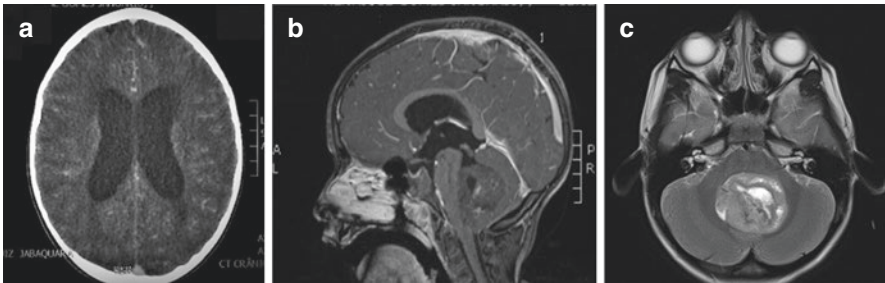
An eleven-year-old boy presenting with headache and vomiting. Imaging exams showing a posterior fossa tumor in the IV ventricle. Pathology demonstrating medulloblastoma. (a) Axial CT scan showing enlargement of the lateral ventricles, Evan's ratio greater than 30%. (b) Sagittal MRI T1-WI contrast enhancement demonstrating a posterior fossa mass, thinning of the corpus callosum and enlargement of the lateral and III ventricles. (c) Axial MRI T2-FLAIR showing a large IV ventricular mass
